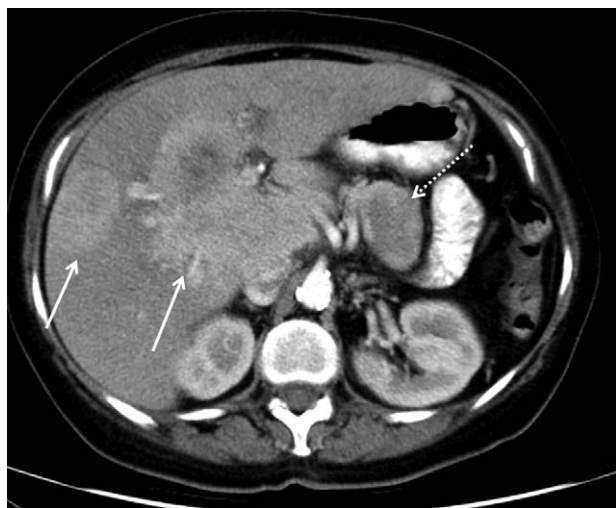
Contrast-enhanced computed tomography (CT) of the abdomen, axial images, post-contrast arterial phase. Multiple hyper-vascular liver masses with central necrosis, measuring up to 14.5 cm (white arrow) and a 4.0 cm nodule in the pancreatic tail (dashed white arrow). Liver enlarged (up to 26 cm). No intrahepatic or extrahepatic dilatation. CT = computed tomography.
